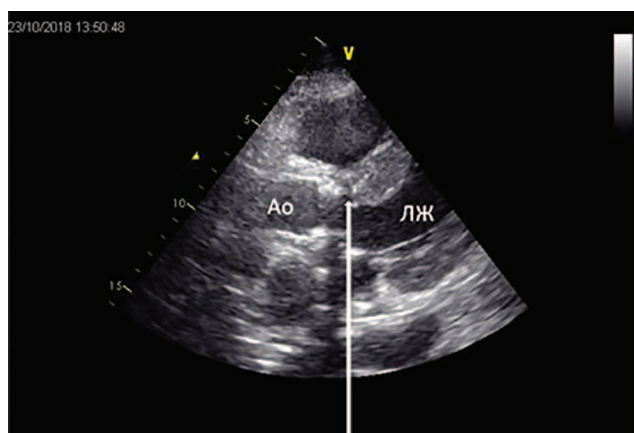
Transesophageal echocardiography of patient P. LV – left ventricle. Ao – aorta. The arrow shows the zone of conduit detachment from the fibrous ring of the aorta
